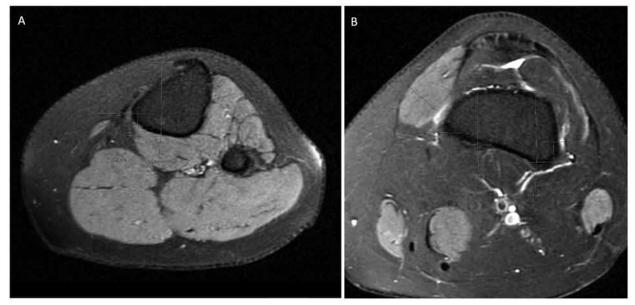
MRI mapping of genicular neurovascular bundles. (A) demonstrated mapped position of the right inferomedial genicular nerve branch, relative to the posterior margin of the tibia. (B) demonstrates mapped positions of the superomedial and superolateral genicular nerve branches, relative to the posteromedial and posterolateral margins of the femur, respectively.
